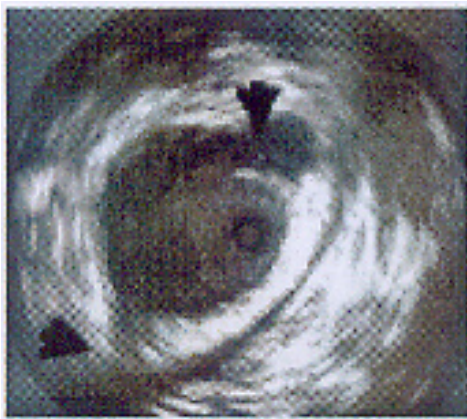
Transesophageal echocardiogram of traumatic thoracic aortic dissection. Upper arrow highlights intimal flap.
